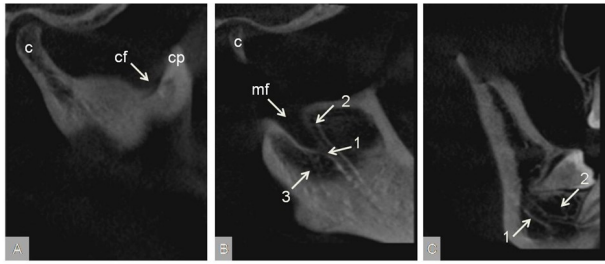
Sagittal Section of CBCT scan: A) showing c condyle; cf coronoid foramen; cp coronoid process. B) showing c condyle; mf mandibular foramen; 1 mandibular canal; 2 & 3 accessory mandibular canals. C) showing 1 mandibular canal; 2 accessory mandibular canal supplying the second molar.
